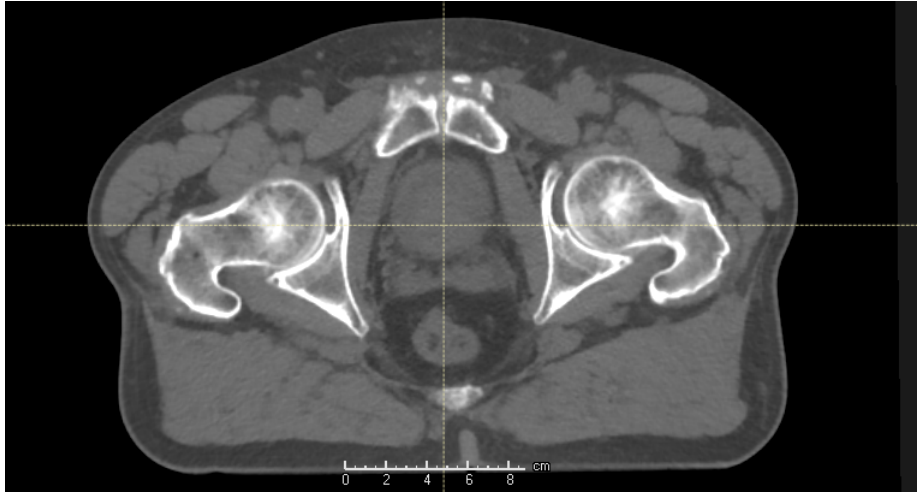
Example of a transverse CT image used for prostate RTP. The femurs are highly visible, as their photon attenuation is very different from the surrounding structures. Soft tissues are however harder to separate based on the CT image alone.
